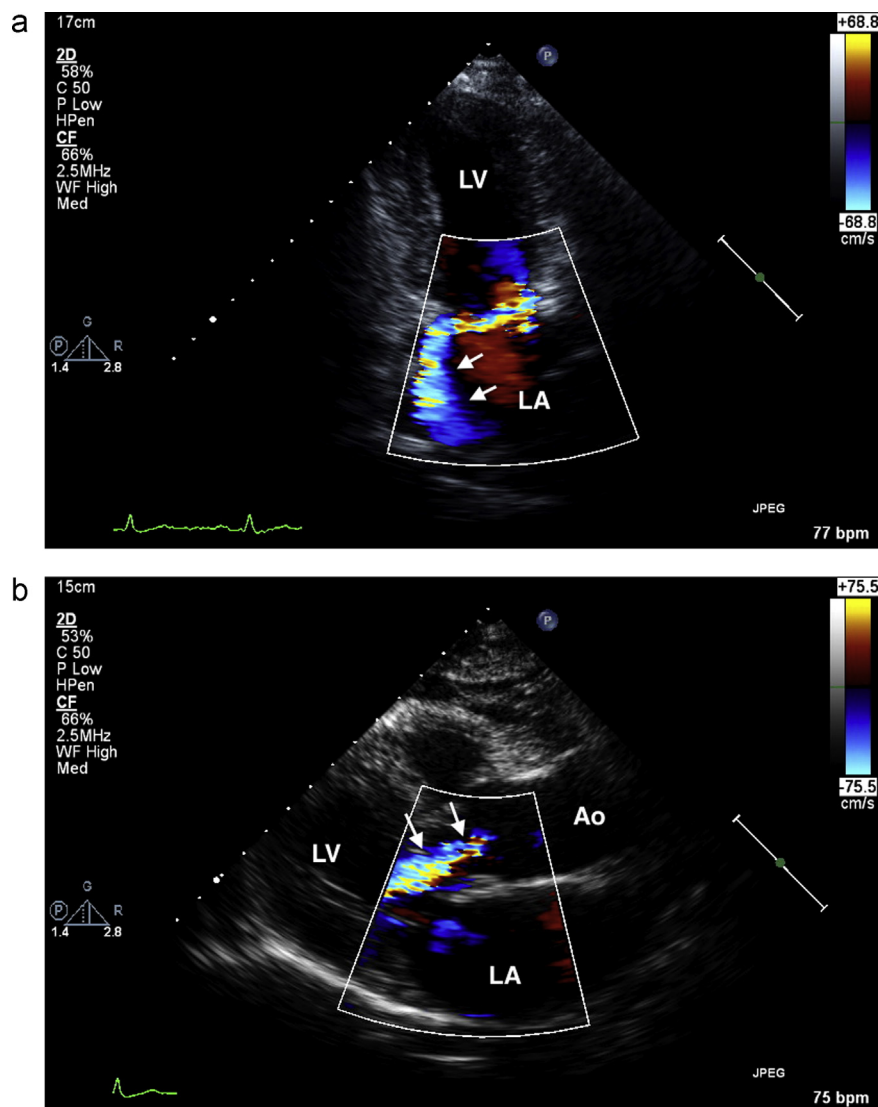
Two-dimensional echocardiography with colour flow Doppler of Case 2 showing (a) an eccentric jet of severe mitral regurgitation (arrowed) and (b) moderate aortic regurgitation (arrowed). Labels: LV, left ventricle; LA, left atrium; Ao, aorta.
